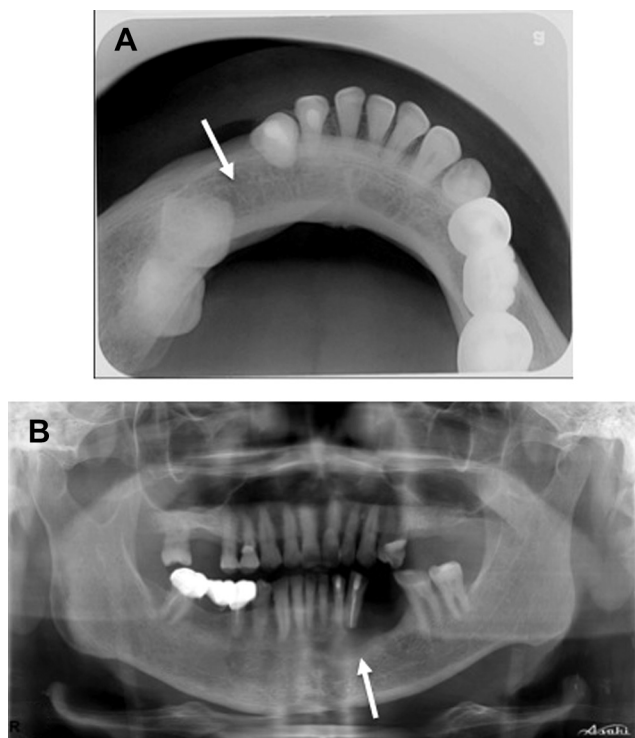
(A) Mandibular occlusal and (B) panoramic radiographs taken 5 months after surgery, showing a well-healed surgical bone defect (arrows).
